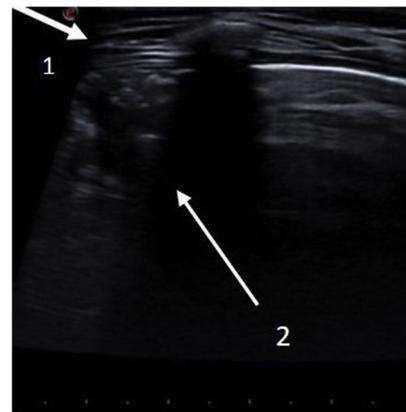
Lung ultrasound, fourth intercostal space at the midclavicular line. Unstructured pleura (arrow 1), with a consolidation pattern (arrow 2) and irregular margin (shred sign) occupying an intercostal space with a depth of 1.2 cm, compatible with incipient pneumonia.
